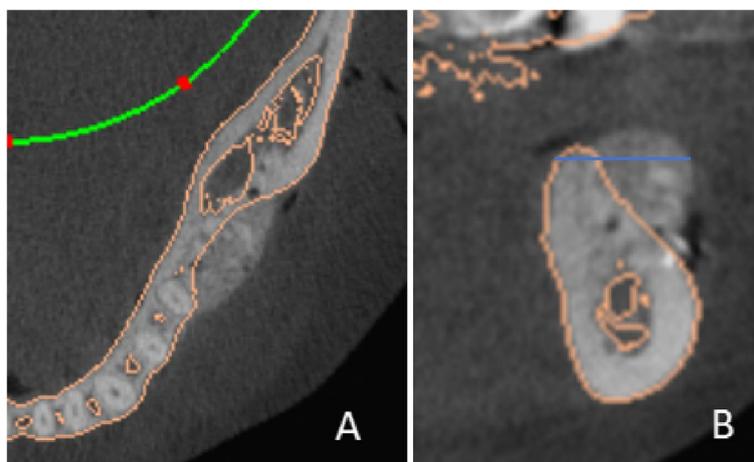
CBCT matching measurements in different periods. A is the cross section after matching, B is the coronal section after matching
